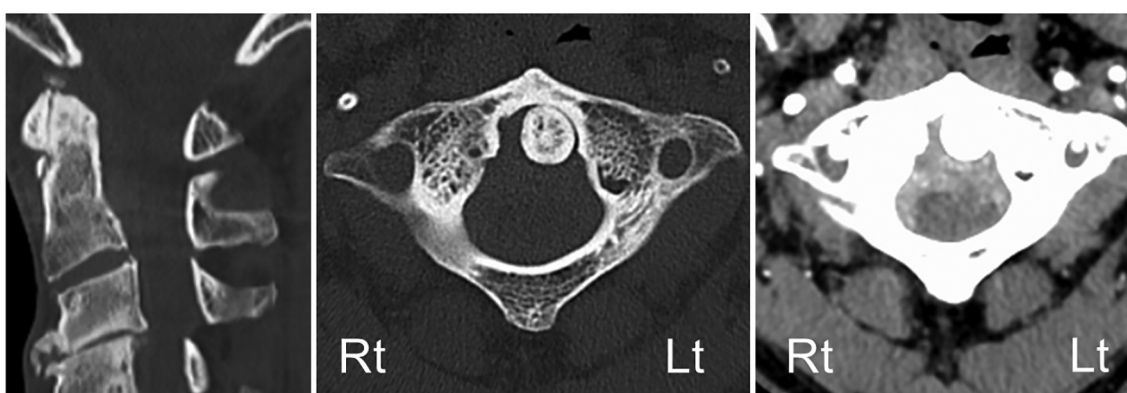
Patient computed tomography (CT) scan. The scan showed no calcification, and a mass without significant contrast enhancement.
